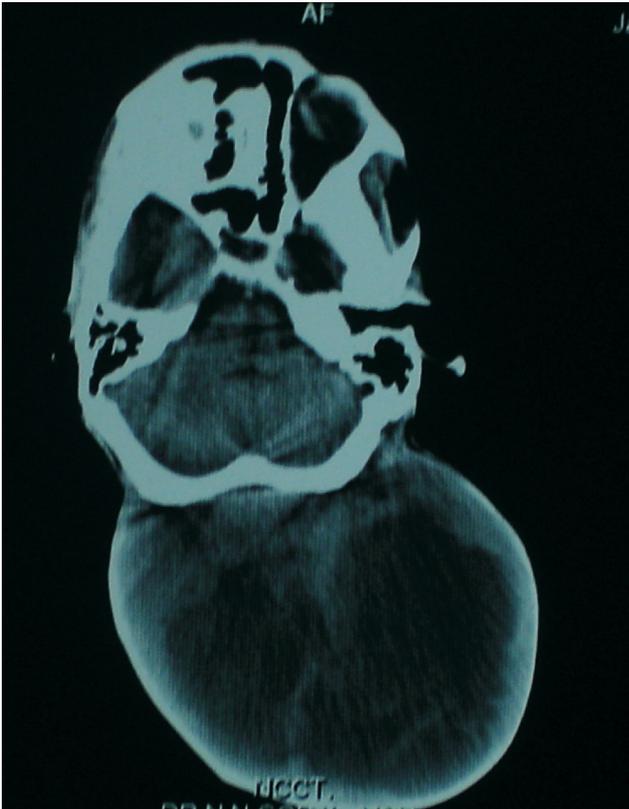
CT scan showing no invasion of the cranium.
